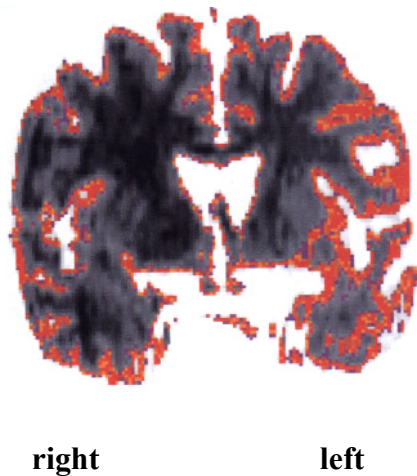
MRI asymmetry of cortical gray mater for a narrow band of pixel intensities is displayed in red false color. In the normal right hemisphere these pixel intensities correspond to a narrow band of surface cortex.
